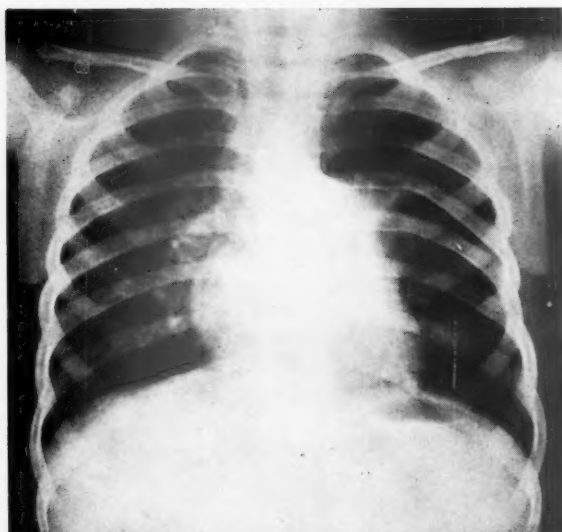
Case 2. Radiograph of chest 20 months after operation.
